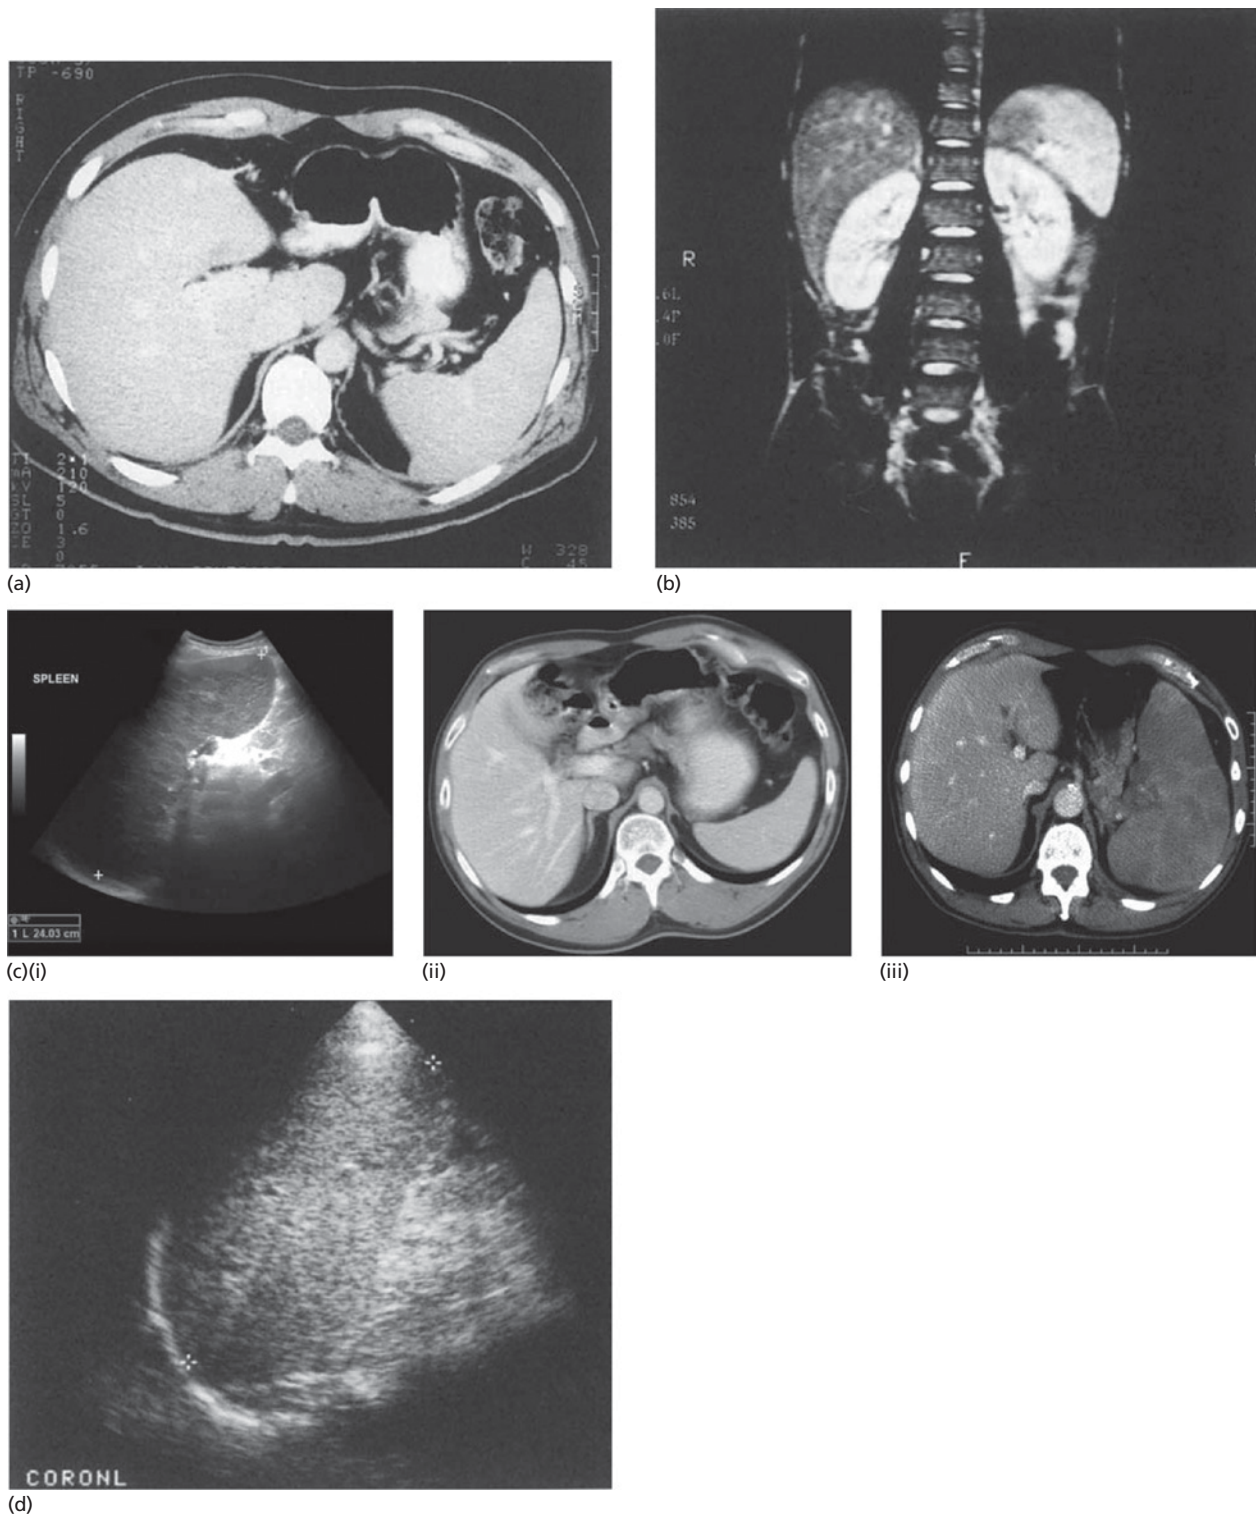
Imaging of the spleen by various methods. (a) CT: transverse section showing liver (left) and spleen (right). (b) MRI: coronal (longitudinal) section showing liver, spleen and kidneys. (c) (i) Ultrasound of spleen showing splenomegaly (15.3 cm); (ii) normal spleen (10 cm) on computed tomography (CT) scan;
